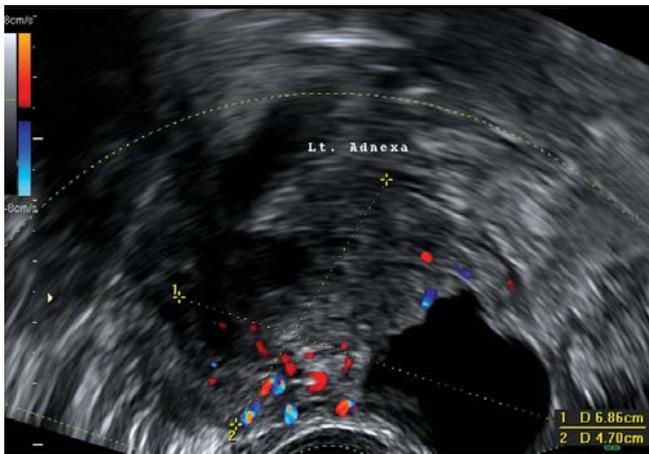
TVS image left ovary. 48-year-old patient with bilateral serous papillary ovarian carcinoma. She had a normal gynecological check-up without ultrasound one year prior to diagnosis. Randomly dispersed vessels in the echogenic area of the adnexal mass
